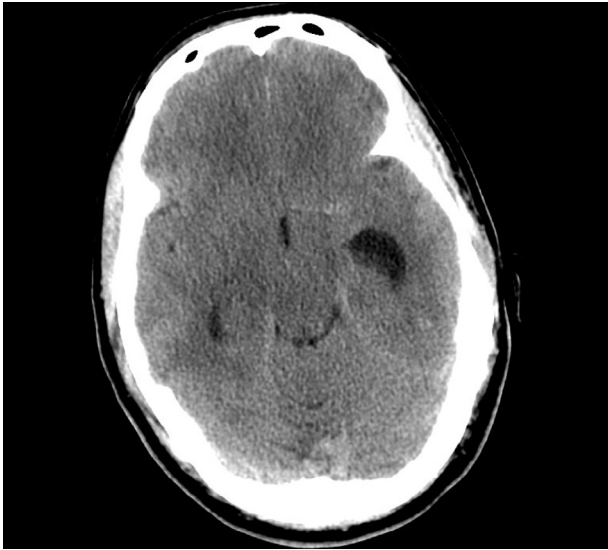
Axial unenhanced CT scan of the head demonstrating asymmetric enlargement of the temporal horn of the left lateral ventricle.
